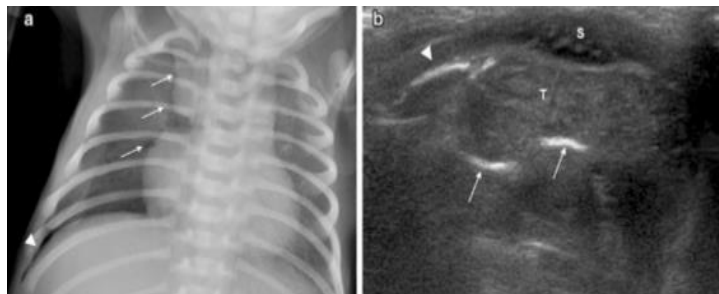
Pneumomediastinum in a 0-day-old boy with dyspnea. Chest radiograph shows an abnormal radiolucency (arrow) along the right border of the thymus and heart. The deep costophrenic sulcus (arrow) on the right indicates a pneumothorax. b Transverse sonogram reveals a thick curved echogenic line (arrow) between the posterior margin of the thymus and the great vessels due to the pneumomediastinum. An echogenic curvature (arrow) also outlines the right anterior lung, possibly due to a combined pneumothorax. T thymus, S sternum^{10,12}
